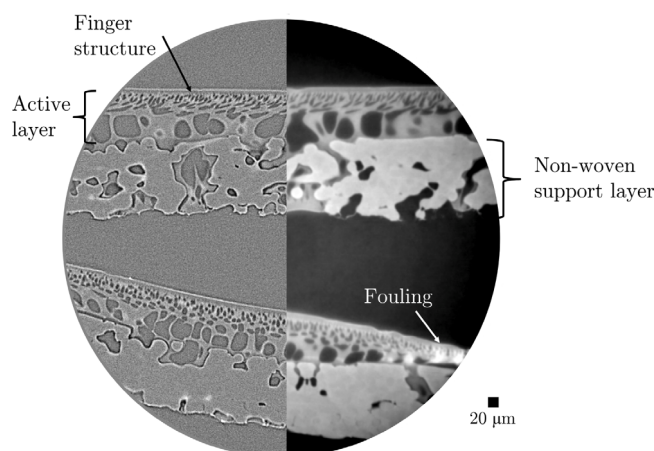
Non-phase retrieved (left) and phase retrieved (right) lab-based  $\mu$ CT reconstructed tomographic slices of a pristine (top) and a used (bottom) UF membrane.
